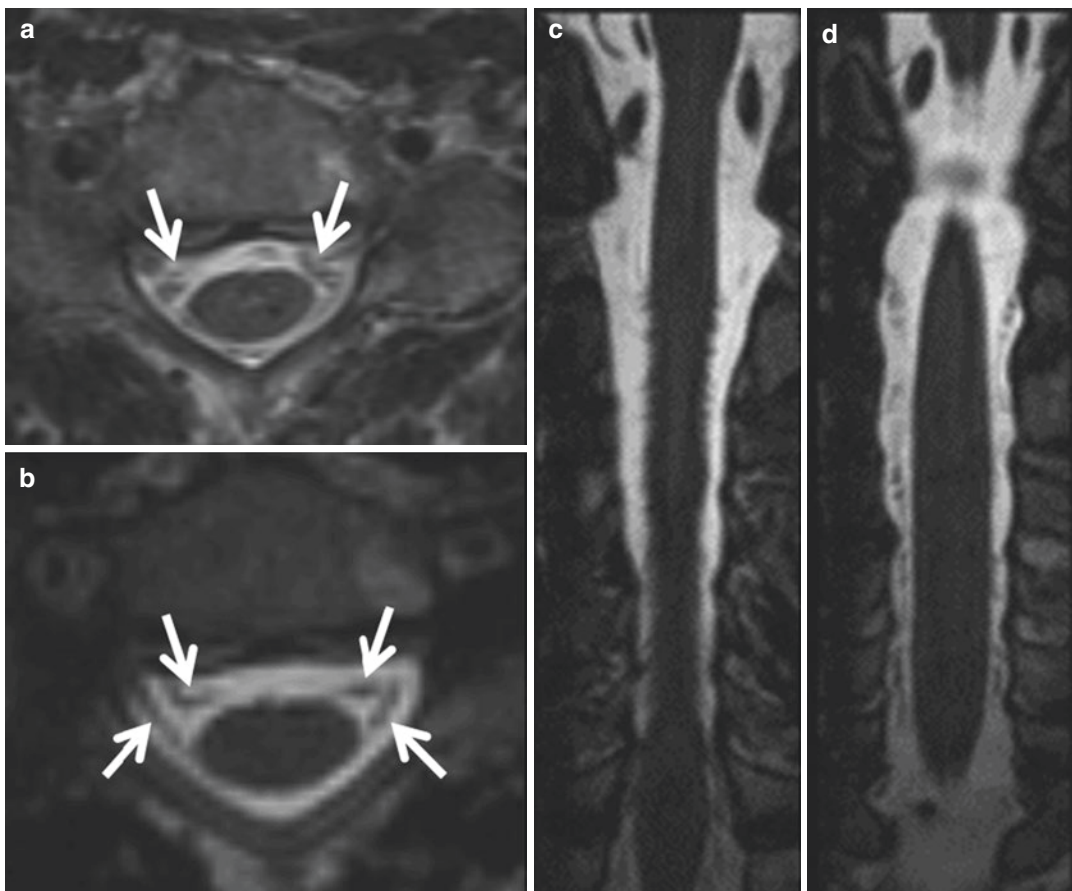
Normal anatomy on axial (a, b) and coronal (c, d) MR images. On a conventional axial T2-weighted image at the C5–6 level (a), the spinal cord is located in the middle of the thecal sac. The nerve roots are not well visualized, in part due to their inherent low resolution and in part due to CSF flow artifact (arrows). At the same level on a high-resolution T2-weighted axial reformatted image (b; SPACE sequence, Siemens, acquired in the sagittal
